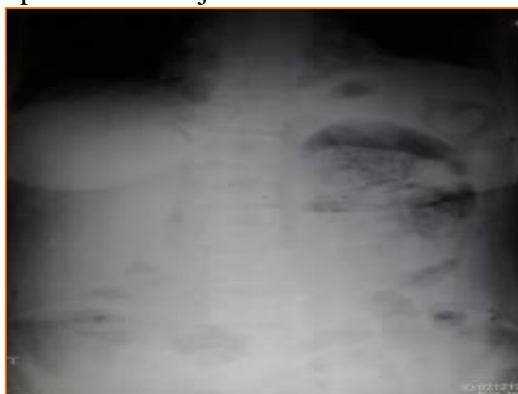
X-ray abdomen showing features suggestive of gas within the left kidney parenchyma.
